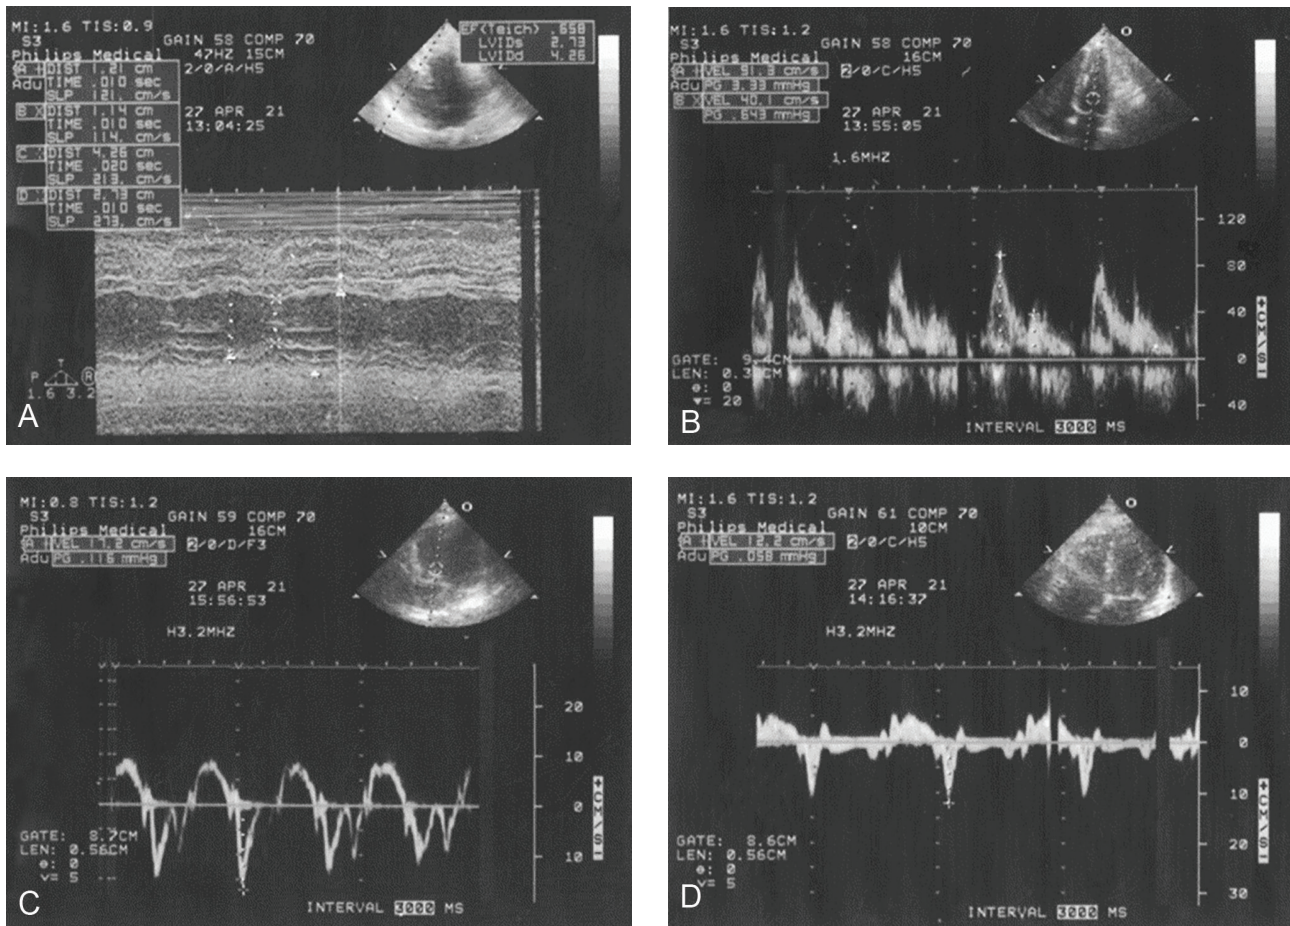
(A) EchoCG of a 23-year-old patient with evidence of physiological LV hypertrophy; (B) 183 diastolic blood flow determined by Pulse-Doppler of the mitral valve; (C) tissue Doppler in the septal 184; (D) lateral segments of the left ventricle.
